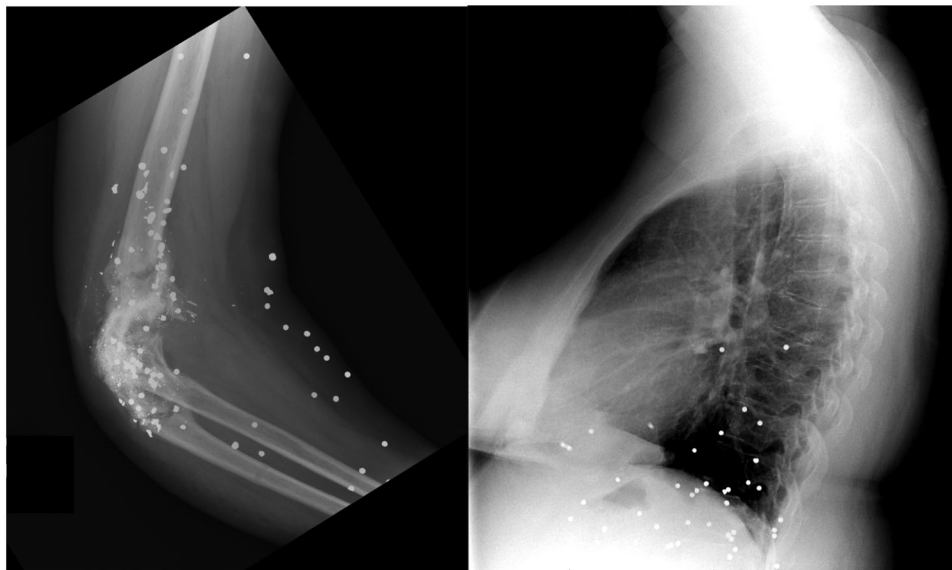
Radiographs of an elbow and chest demonstrating multiple pellets and difficulty with surgical removal because of anatomical location and fragmentation. Consent to publish this image was obtained directly from the patient.
